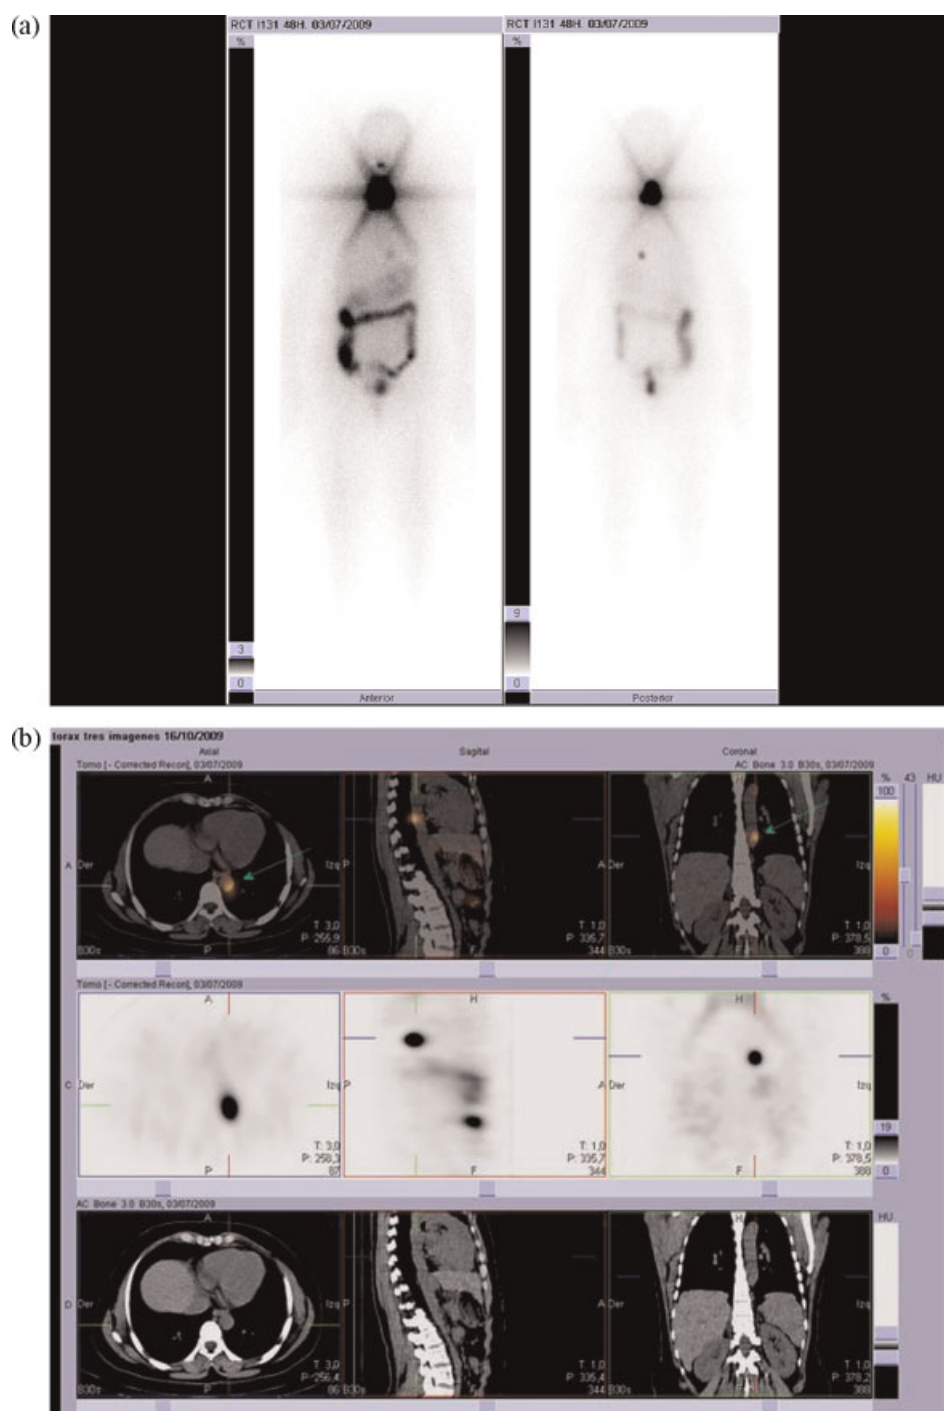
SPECT-CT in a patient with total thyroidectomy for differentiated thyroid carcinoma after ^{131}I ablative treatment. (A) The post-treatment SPECT scan shows a chest focus uptake. (B) The focus is localized by SPECT-CT in the left hemithorax, near the thoracic aorta (pulmonary nodule with a positive uptake of radioiodine). Courtesy of Virgen de las Nieves Hospital, Granada.
